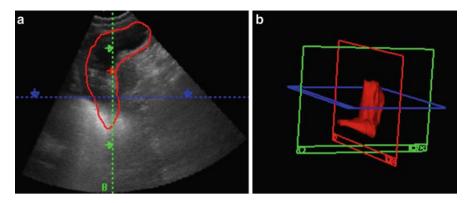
Ultrasonographic image of the stomach, following 3D reconstruction, demonstrating (a) region-of-interest and (b) 3D reconstructed volumetric image of the stomach
